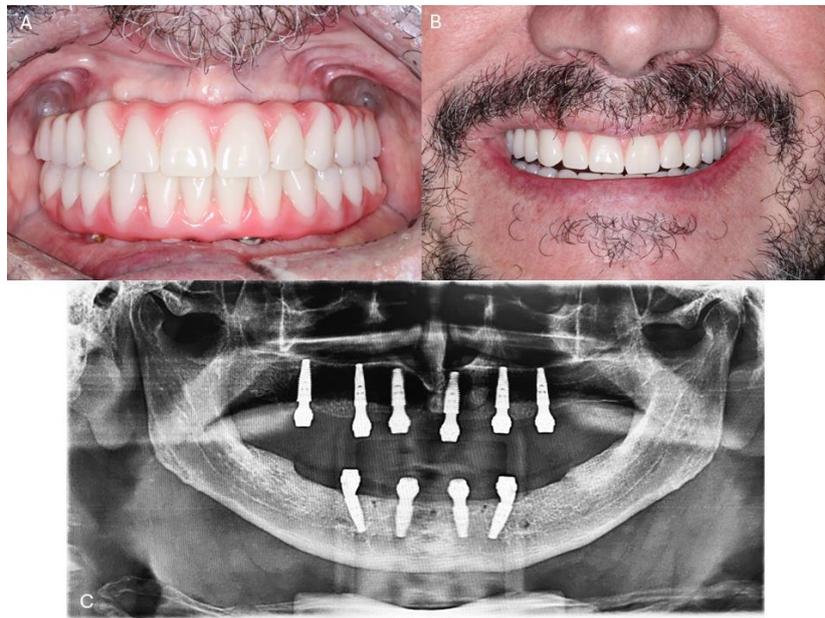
(A) Definitive prostheses installed; (B) Final smile appearance after installation of the definitive prostheses. (C) Panoramic X-ray taken after prostheses installation.
